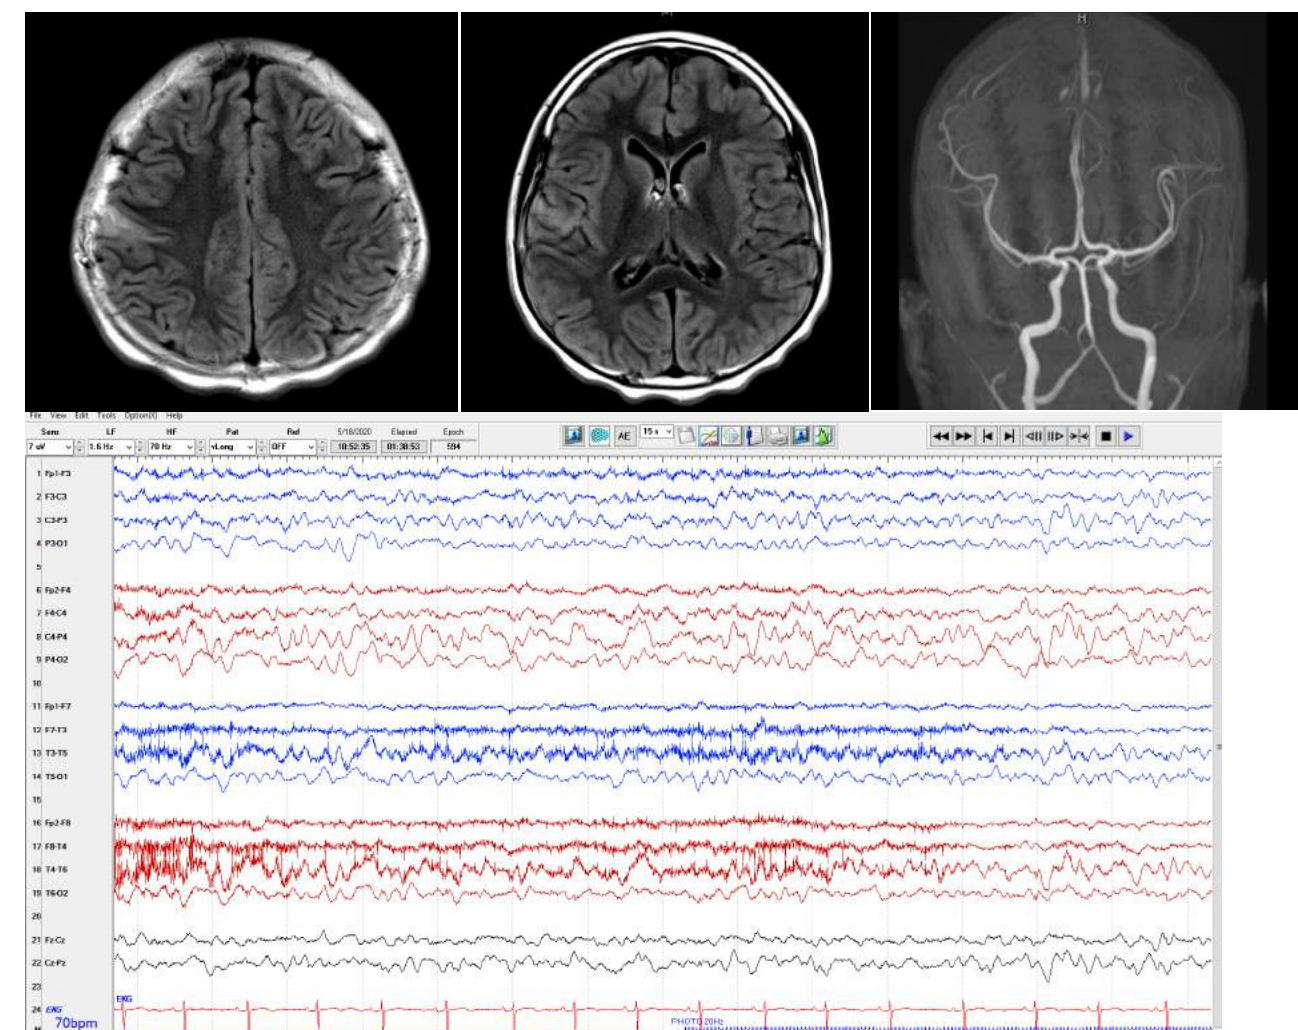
FLAIR images reveal moderate edema involving the cortex and subcortical white matter of right postcentral gyrus. MRA is normal. No diffusion restriction seen in ADC map. EEG: Slow disorganized background which is more prominent over the right posterior quadrant.
